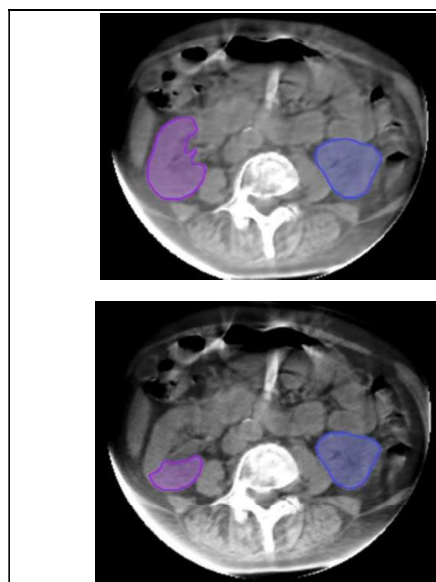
Example of contouring accuracy improvement with CBCT enhancement.
